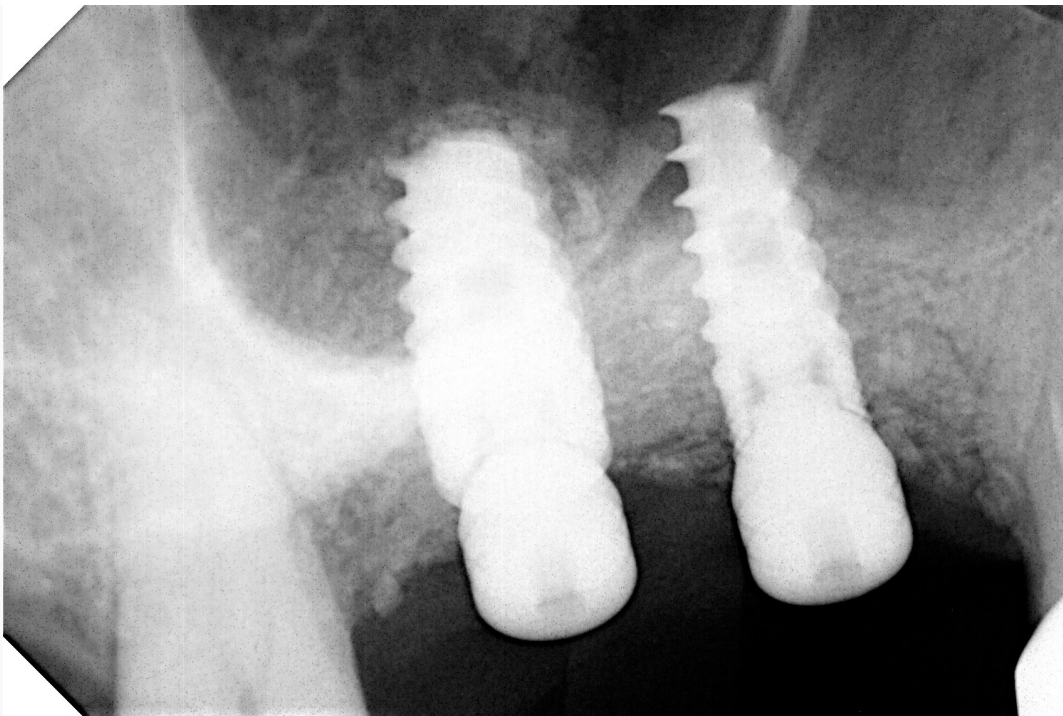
Periapical radiograph taken following additional sinus elevation and implant placement.
